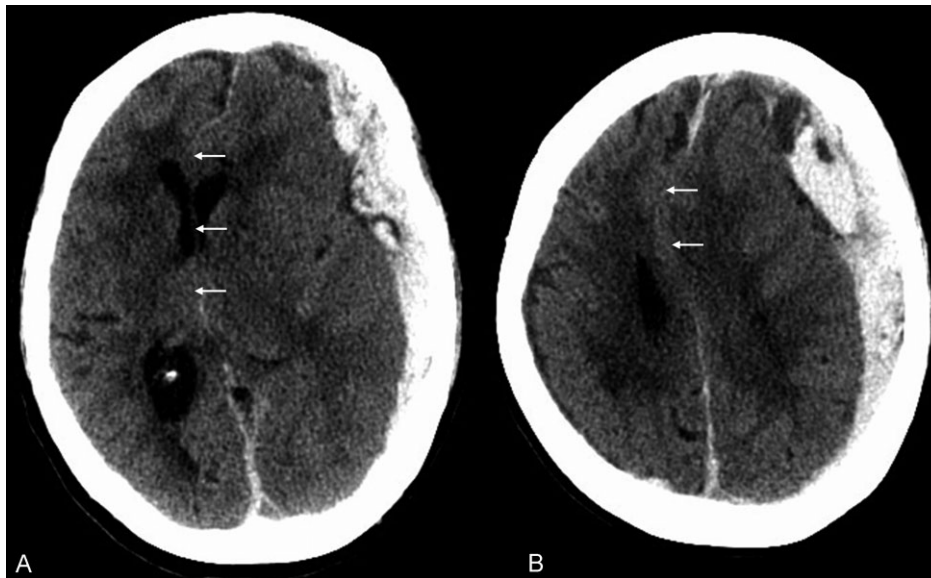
Subfalcine herniation due to a subdural hematoma. The axial computed tomography images show an acute, left, heterogeneous, holoemispheric subdural hematoma with associated sulcal effacement, midline shift, and left-to-right subfalcine herniation (arrows).
